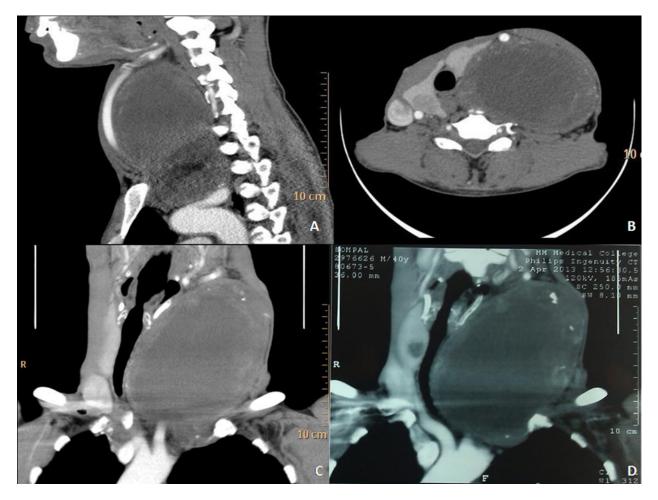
A, B, C, D CT scan showing the extent of the tumor
